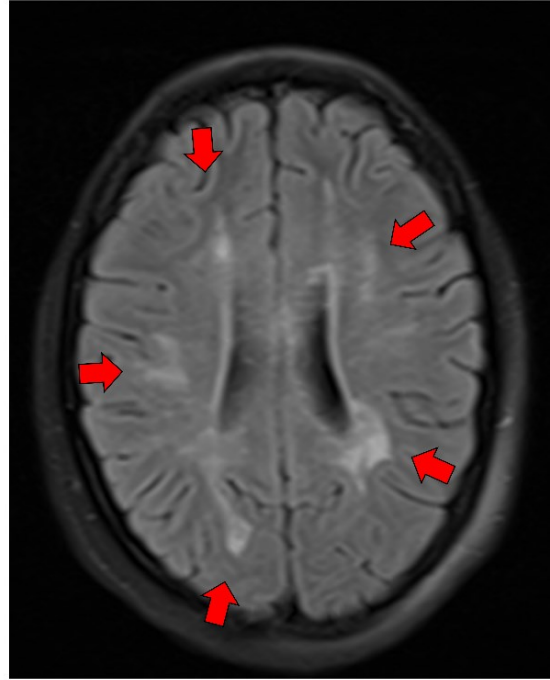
non-specific white matter lesions on FLAIR sequence in axial plane
